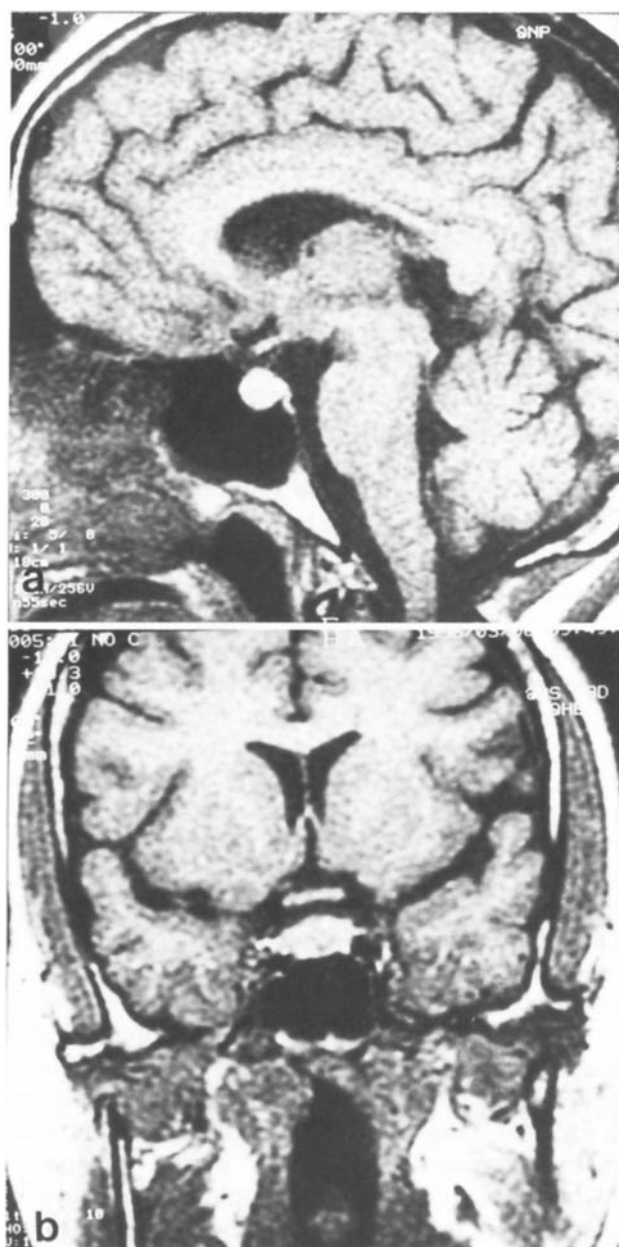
MR images of the pituitary gland in sagittal and coronal views during the first day *post partum* show a round appearance (a) and marked convexity (b) of the upper border of the pituitary gland.
